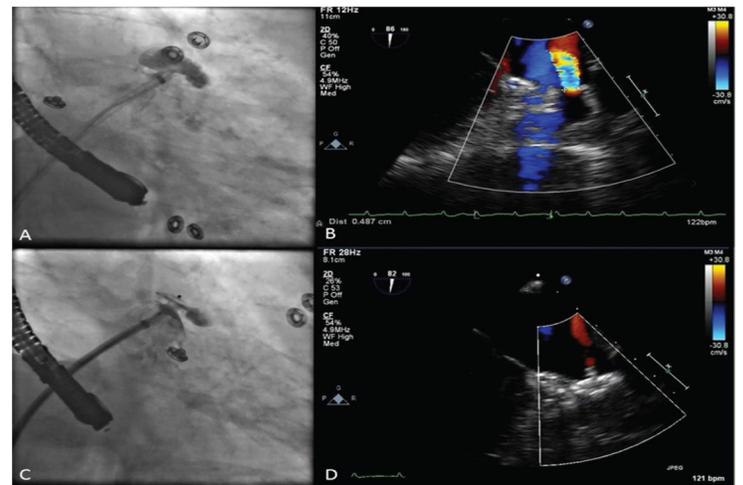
Panel A shows remnant connection between left atrium and LAA after contrast injection. Panel B shows the same leak on TEE. Panel C shows ASO device obliterating the remnant connection between the LA and the appendage after contrast. Panel D shows TEE images of the ASO device in situ. LAA= Left atrial appendage, ASO = Amplatzer septal occluder, TEE = Transesophageal echocardiogram
